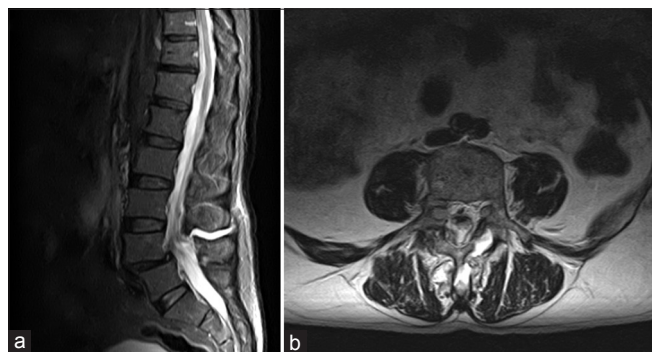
Sagittal STIR (a) and axial T2-weighted (b) MRI of the lumbar spine showing L4–L5 isthmic spondylolisthesis with an interspinous fistulous tract through interspinous processes and a posterior paravertebral collection compatible with CSF
